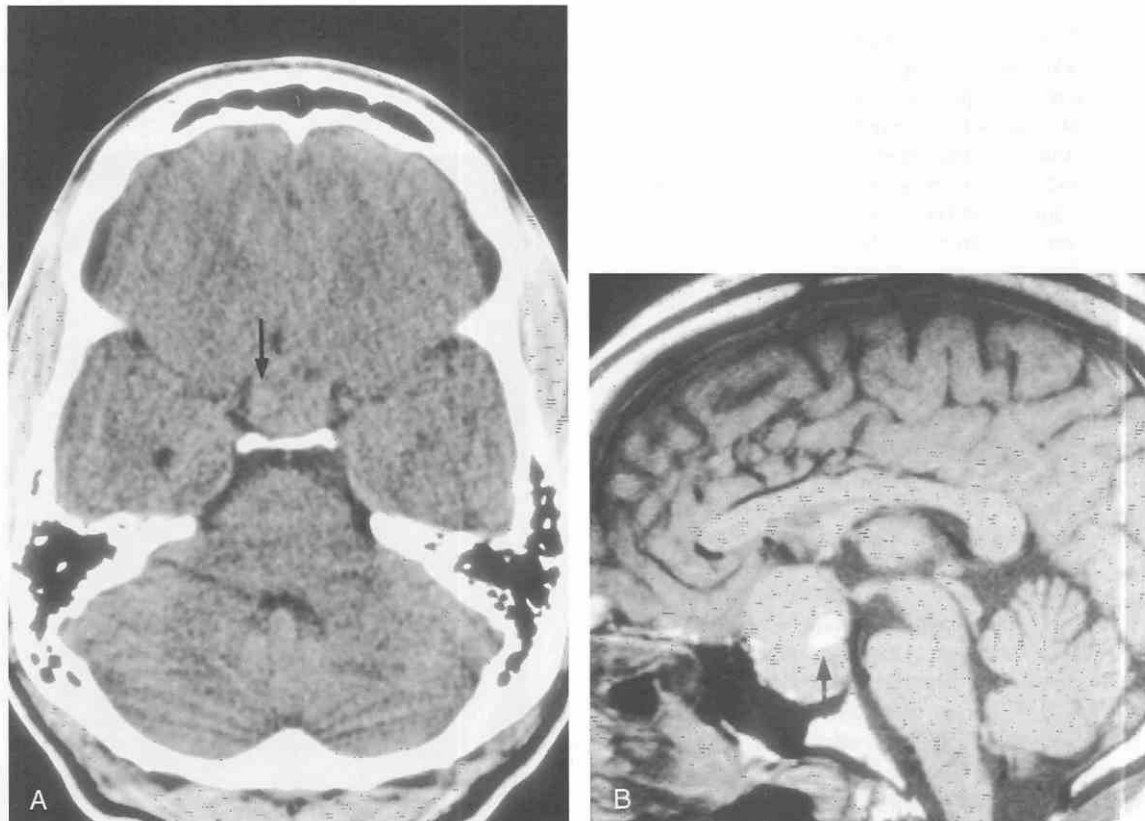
Pituitary macroadenoma with intratumoral hemorrhage and cystic changes. A, Axial noncontrast CT image demonstrates a soft tissue mass filling the suprasellar cistern. The tumor is mainly isodense with adjacent brain, but a faintly hyperdense focus at the right lateral margin (arrow) suggests recent hemorrhage. On a sagittal T1-weighted MR image (B), the tumor is seen to enlarge the sella and extend into the suprasellar cistern, elevating and slightly posteriorly displacing the optic chiasm and the anterior floor of the third ventricle. It is mainly homogeneously isointense with adjacent brain, but contains several hyperintense foci (the largest is located in the posterior portion of the tumor and is indicated by an arrow) which likely represent subacute hemorrhage.
